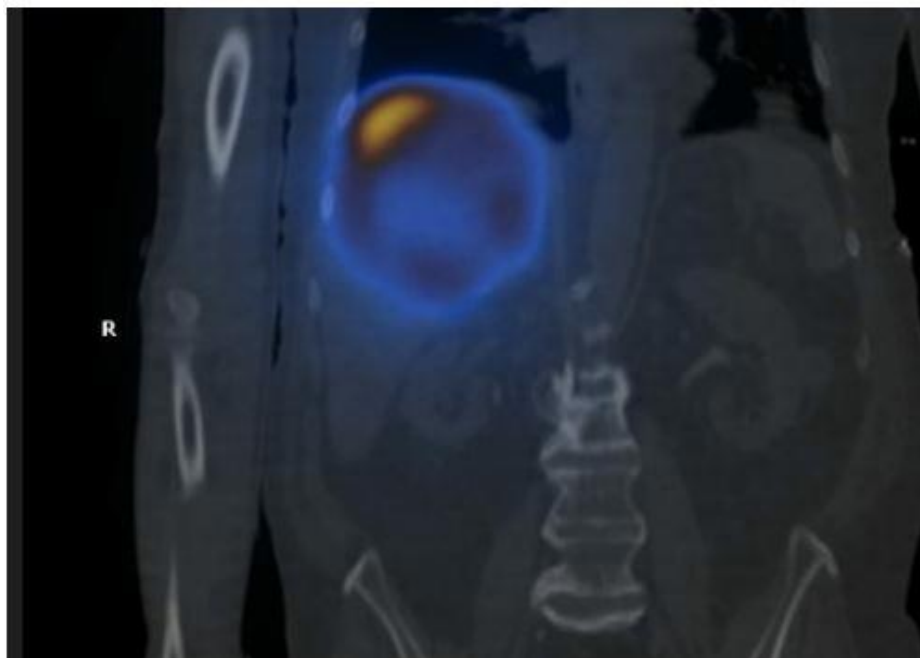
Coronal SPECT Post Initial Y-90 therapy
